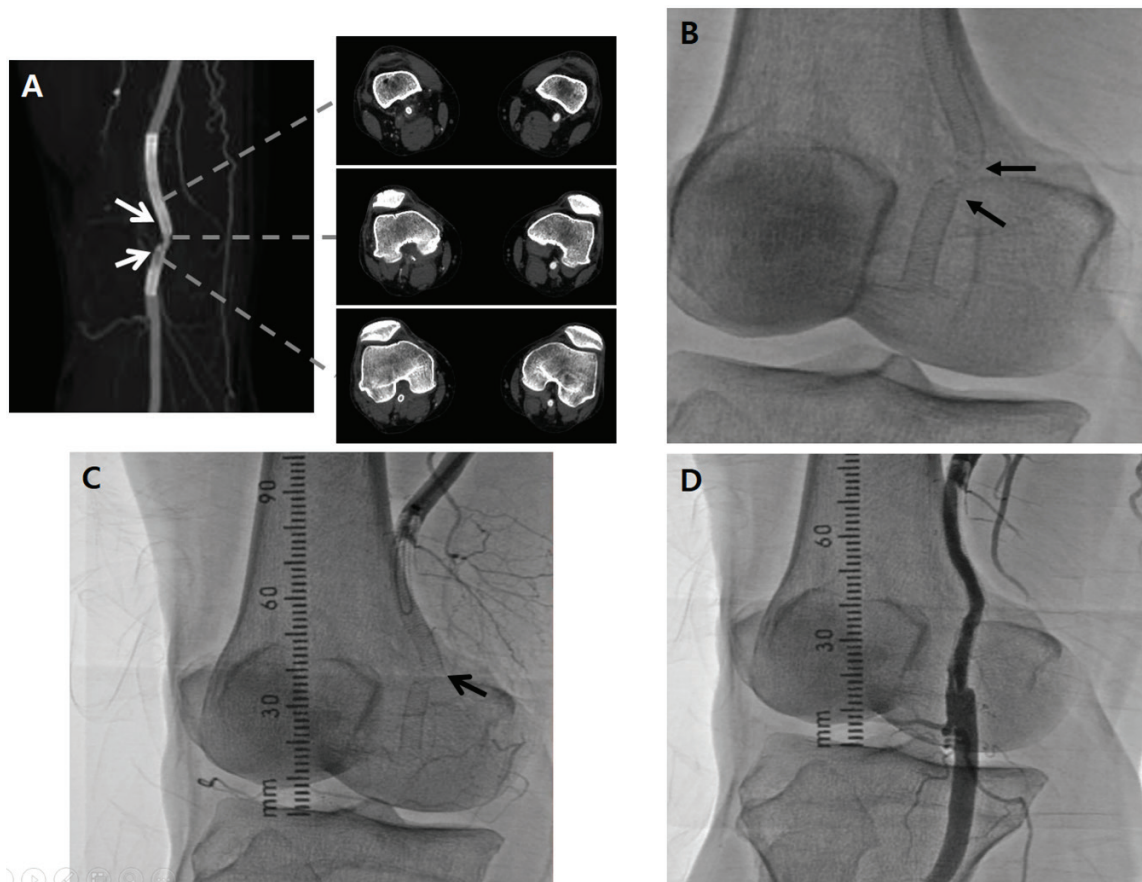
Supera stent fracture. There is a definite stent fracture observed on computed tomography (A, between white arrows) and fluoroscopy (B, between black arrows). The percutaneous transluminal angiography is performed (C, right popliteal artery is completely occluded and black arrow demonstrates a stent fracture) and successful revascularisation is shown (D).
